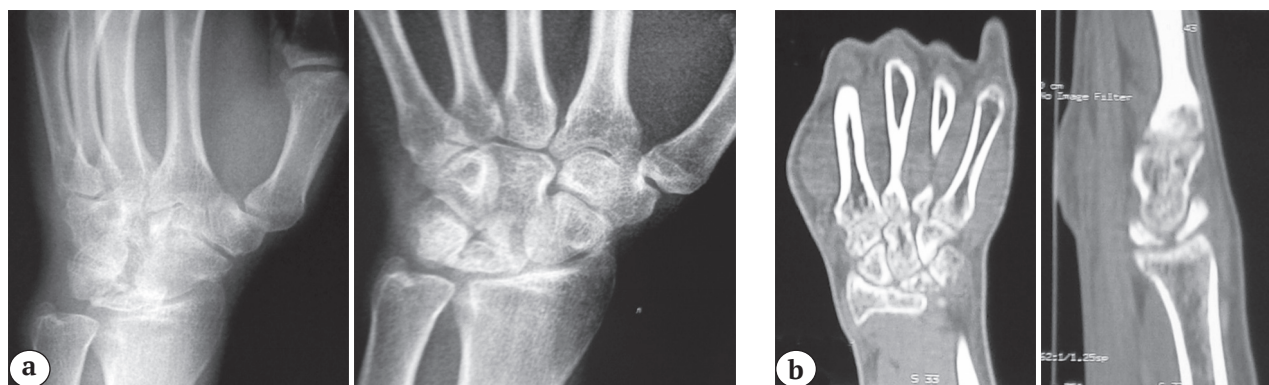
X-rays and CT of the left wrist of the patient, 21 years old, on admission: a – X-ray of the left hand (AP and lateral planes): signs of aseptic necrosis, fragmentation of the lunate, “negative ulnar variance”; b – CT of the left wrist: signs of aseptic necrosis of the lunate, stage IIIb.
